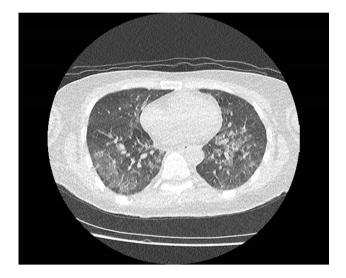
Chest computed tomography scan of patient 3. 50–75% of lungs are showing typical bilateral ground-glass opacity and pulmonary consolidation
